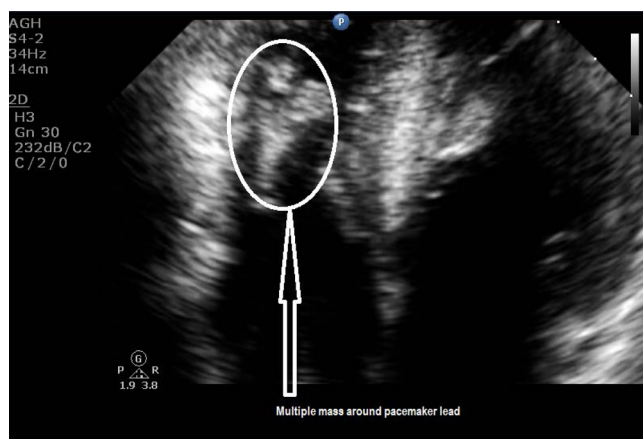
Echocardiography showing multiple mass around pacemaker lead.
